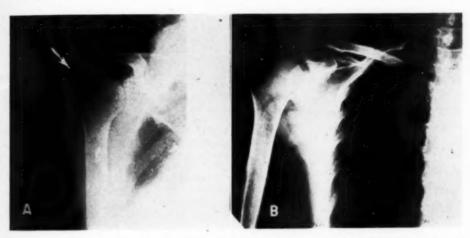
Bursitis, Case 2. A. Roentgenogram taken on March 29, 1946, showing calcium deposit (arrow). B. Roentgenogram taken on May 20, one month after the last treatment, showing little evidence of residual calcification.
